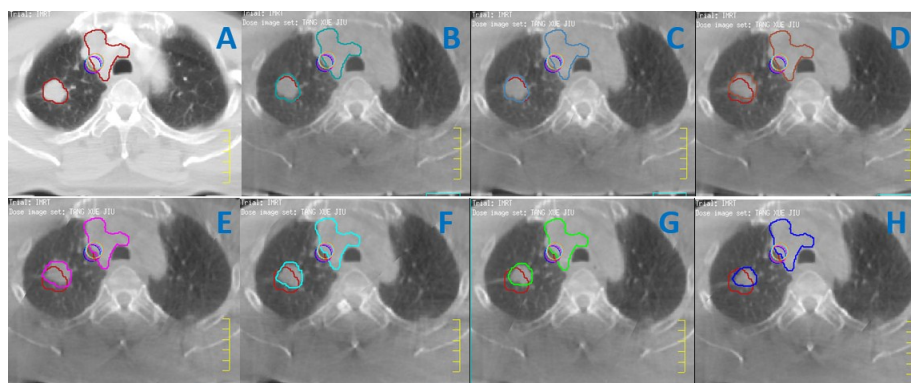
GTV contoured on planning CT (A); GTV₁ contoured on 1st CBCT scanning before 1st treatment (B); GTV₂ contoured on 2nd CBCT scanning before 6th treatment (C); GTV₃ contoured on 3rd CBCT scanning before 11th treatment (D); GTV₄ contoured on 4th CBCT scanning before 16th treatment (E); GTV₅ contoured on 5th CBCT scanning before 21th treatment (F); GTV₆ contoured on 6th CBCT scanning before 26th treatment (G); GTV₇ contoured on 7th CBCT scanning before 30th treatment (H).
